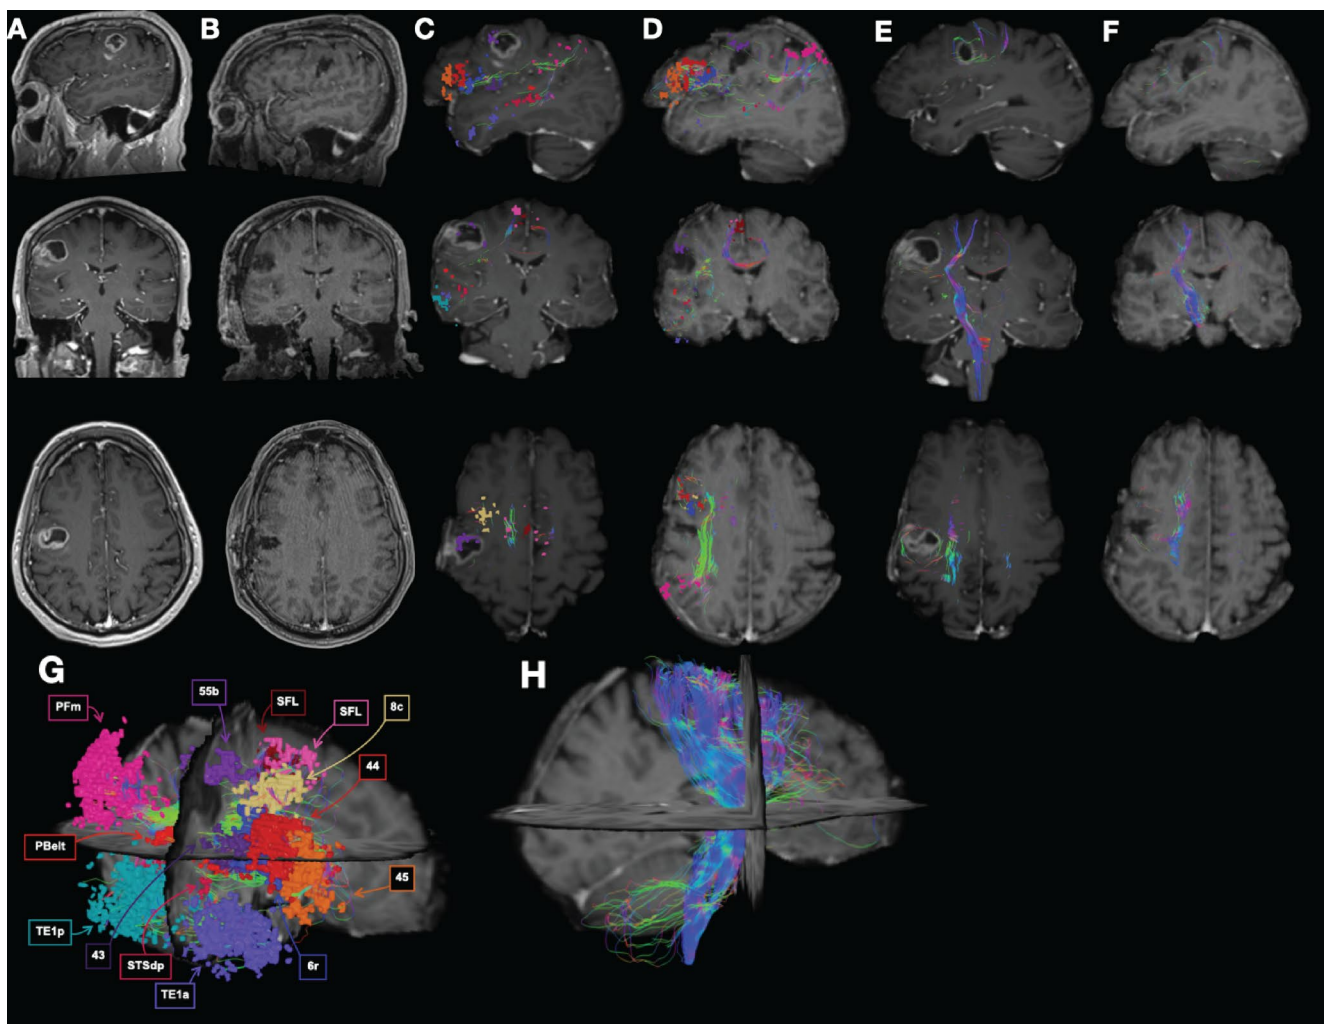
A: Multi-planar reconstructions of a thin cut T1 Post MRI sequence 1 day prior to resection in a 69 year-old male. B: Same sequence from the post-op day 1 MRI. Pathology was consistent with Glioblastoma WHO Grade IV. C: DWI sequences from the preoperative MRI in part A were used to identify structural connectomics parcels related to language function around the lesion, to aid with planning a surgical approach. D: Those same parcels are shown based on
